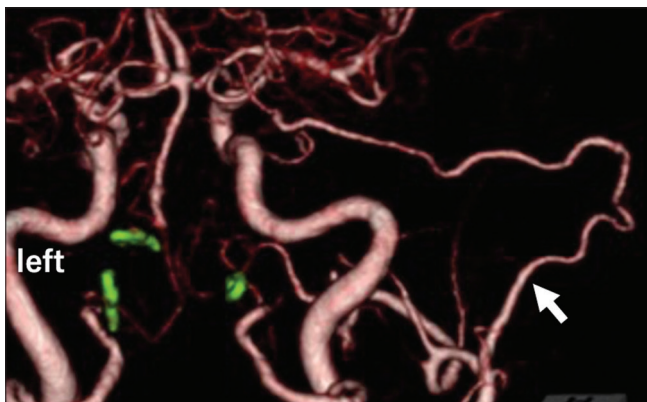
Posterior view of computed tomography angiography demonstrates bilateral vertebral dissection aneurysm obliteration and patent superficial temporal artery–superior cerebellar artery bypass graft (arrows).
